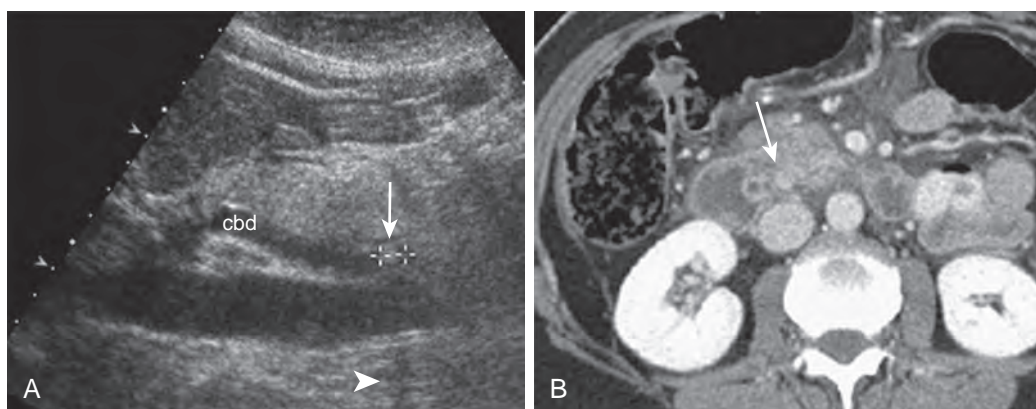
Choledocholithiasis: ultrasound and CT findings. A. Ultrasound demonstrates dilated common bile duct (cbd) with small stone located distally (arrow). Note posterior acoustic shadowing (arrowhead). B. Contrast-enhanced CT demonstrates small distal stone (arrow) that was not identified prospectively.
